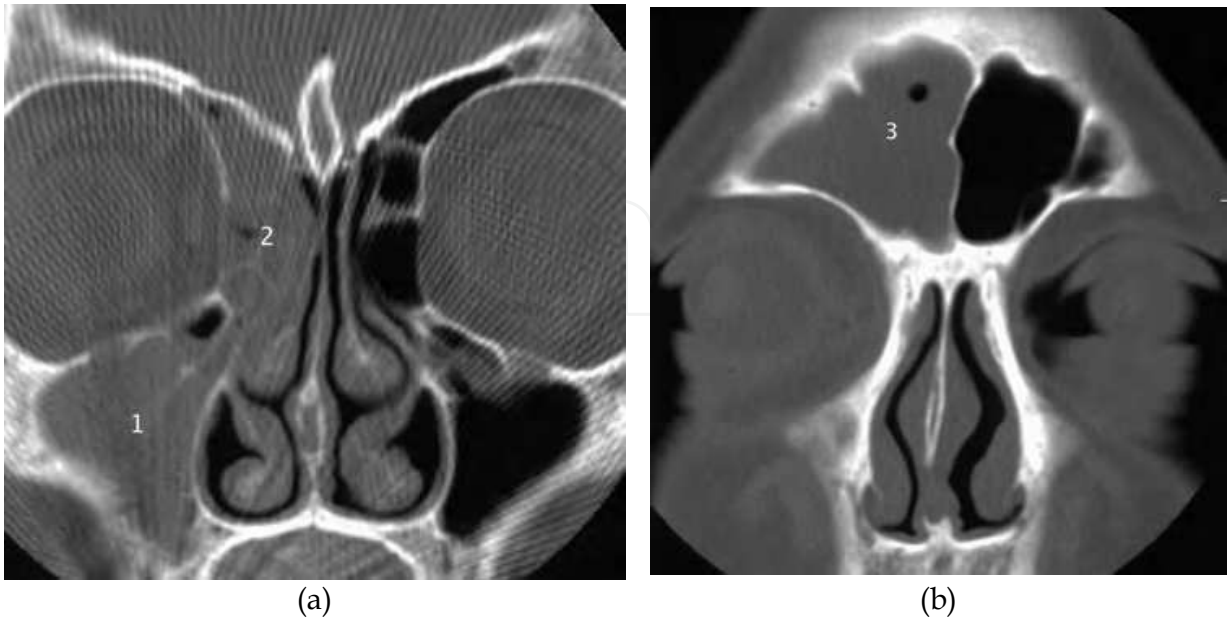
Coronal CT shows OMC inflammatory pattern with ipsilateral opacification of the (a) maxillary (1), anterior ethmoid (2) and (b) frontal sinuses (3).
